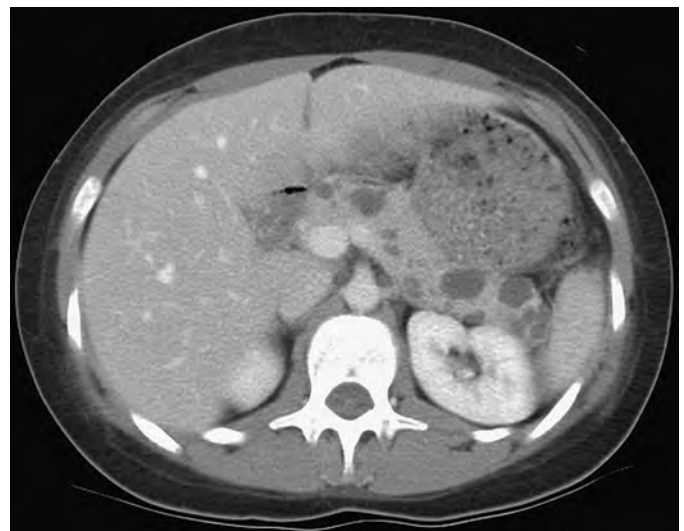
Pancreatic cysts in von Hippel-Lindau disease. The CT scan demonstrates numerous, small cysts within the pancreas in a young woman with von Hippel-Lindau disease.
